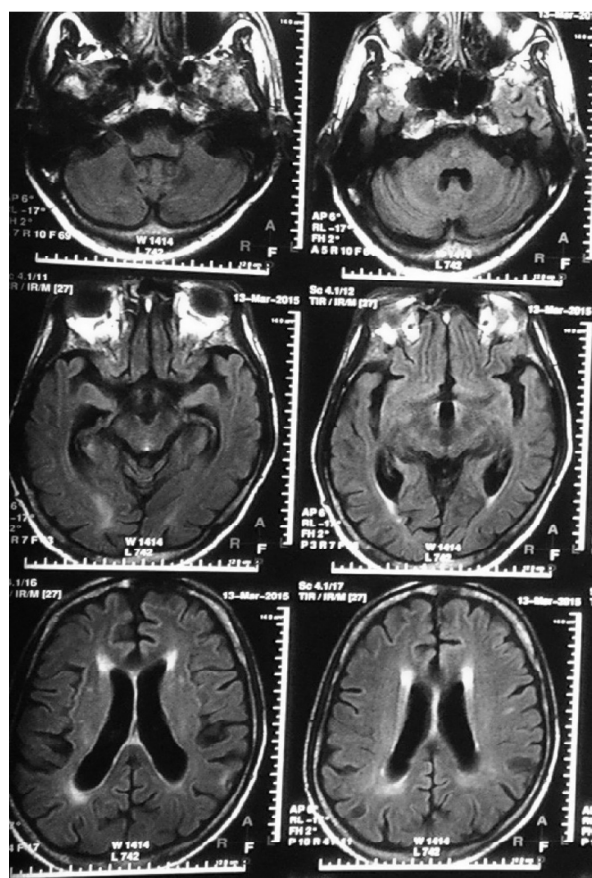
MRI findings of the patient showing hyperintensities and T1 weighted images
